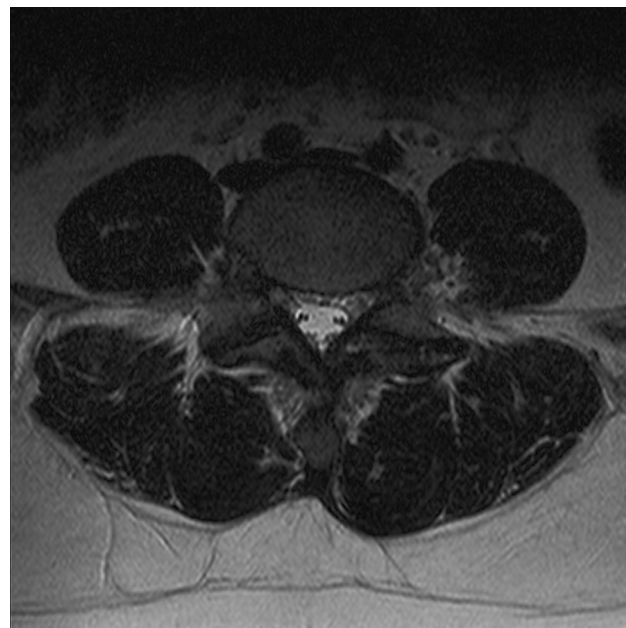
Magnetic resonance imaging showing lumbar spondylosis affecting left L4–L5 zygapophysial joint.
